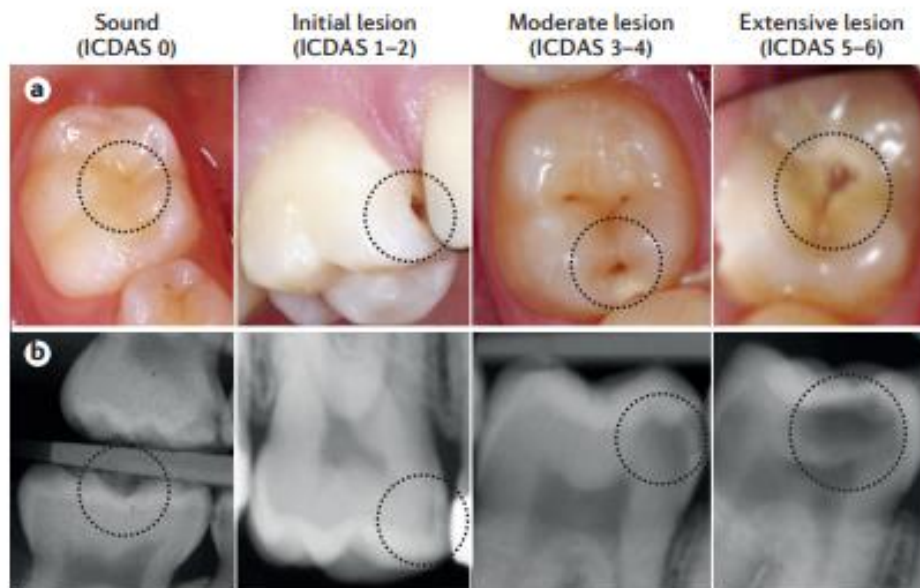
Clinical and radiographic appearance of the stages of severity of tooth decay. Clinical appearance (part a) and bite-wing radiograph (part b) of the same tooth. Examples of sound and extensive caries surfaces are shown on the biting (or occlusal) surfaces, which contain developmental depressions and grooves (known as pits and fissures) that collect dental biofilm and are caries predilection sites. The initial-stage and moderate-stage lesion examples show approximal surfaces (where adjacent teeth are in contact). Caries also develops on the free smooth surfaces (adjacent to the cheeks, lips and tongue).
